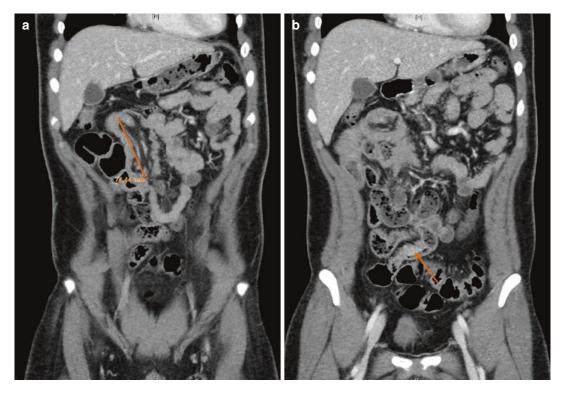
Small bowel intussusception in abdominal computed tomography. (a) Intussusception is noted to be at least 15 cm in length in the small bowel (arrow). (b) Multiple polyps are observed in the small bowel
